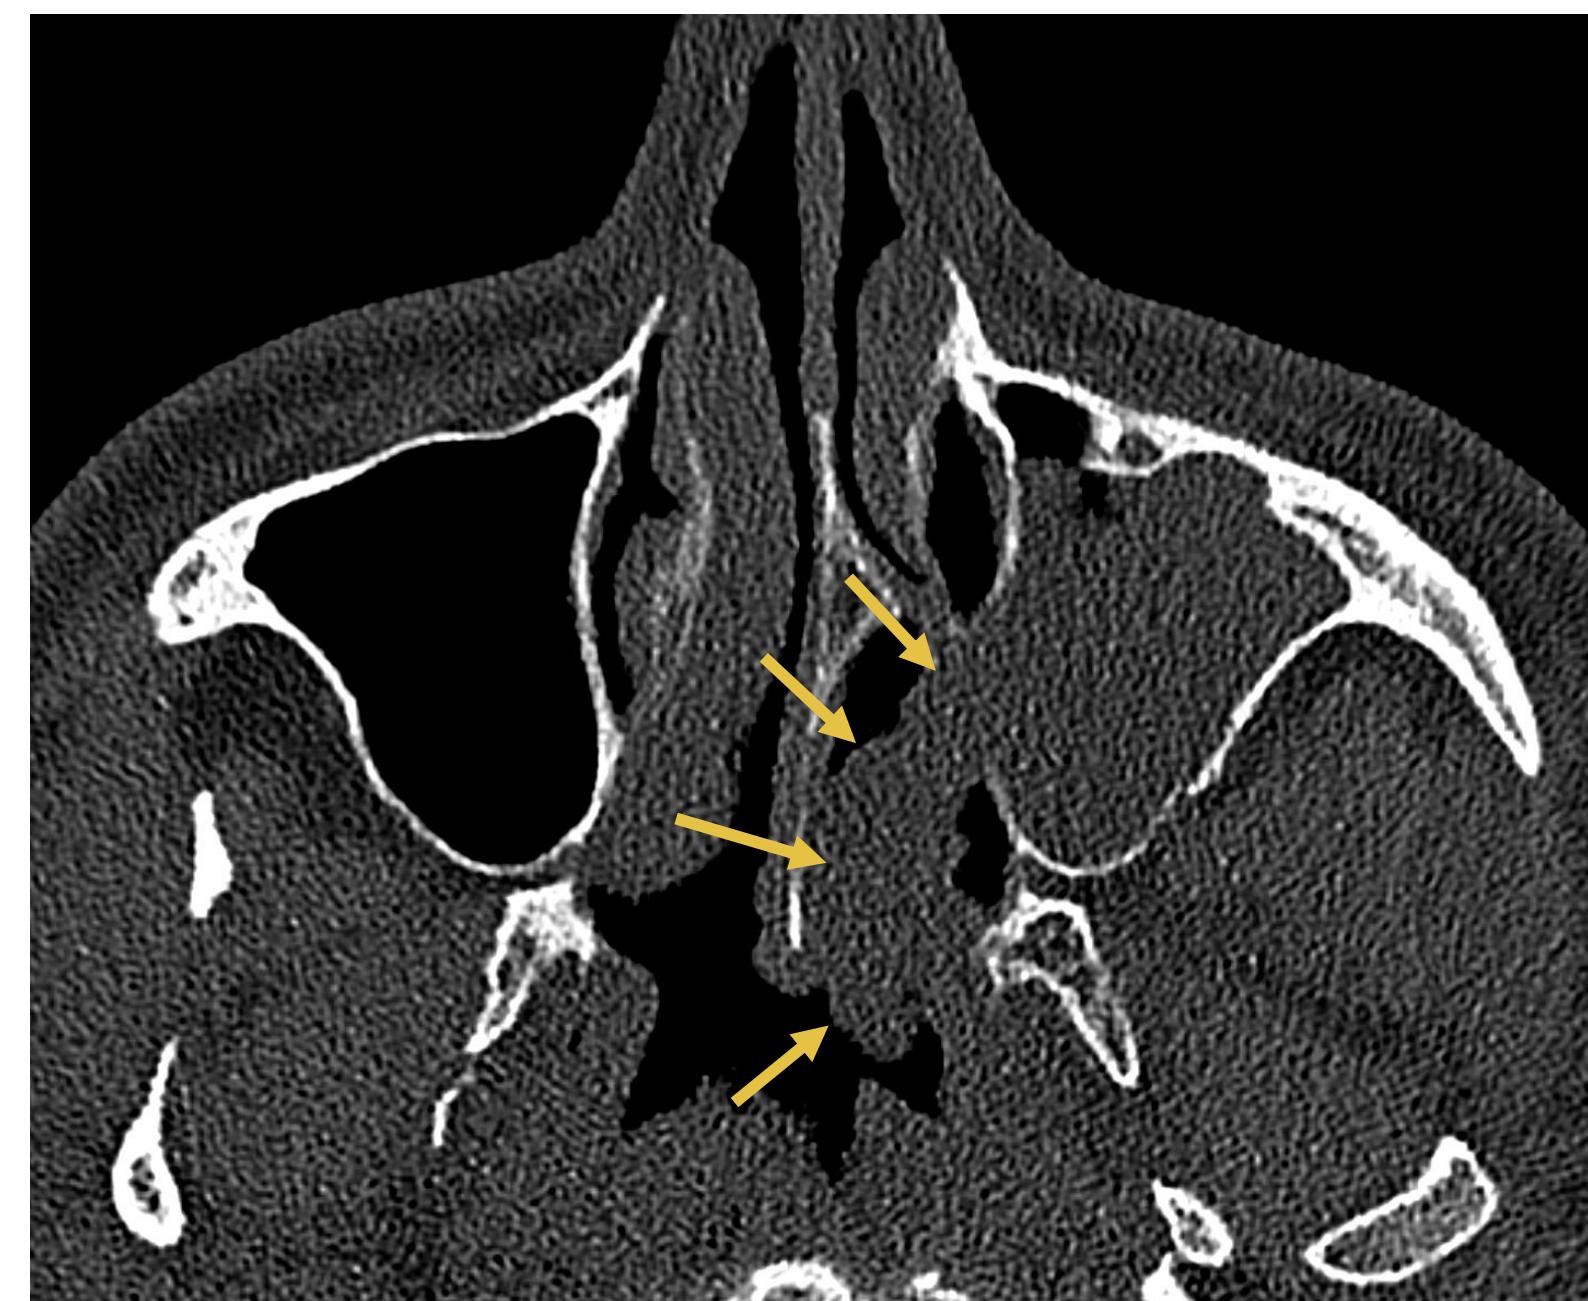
Axial CT in the bone window shows a polypoid mass in the left maxillary sinus and nasal cavity extending into the nasopharynx (arrows); with no aggressive osseous erosion, suggesting a benign etiology.
